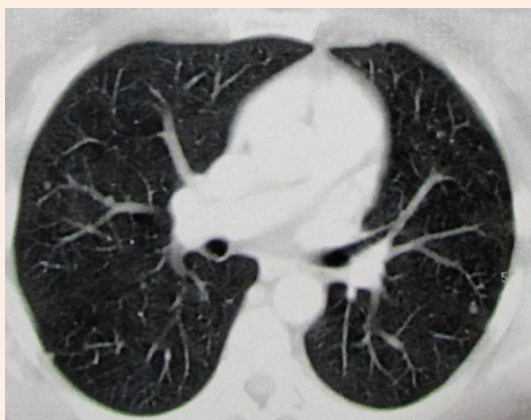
Chest CT scan showing multiple infra centimetric bilateral pulmonary nodules.
